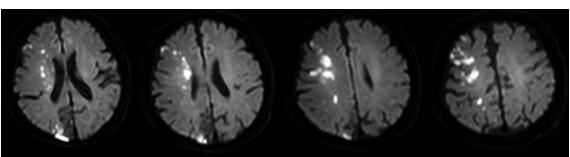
Series of diffusion-weighted MR images of the brain show multiple acute infarctions in the right middle cerebral artery and watershed territories.
